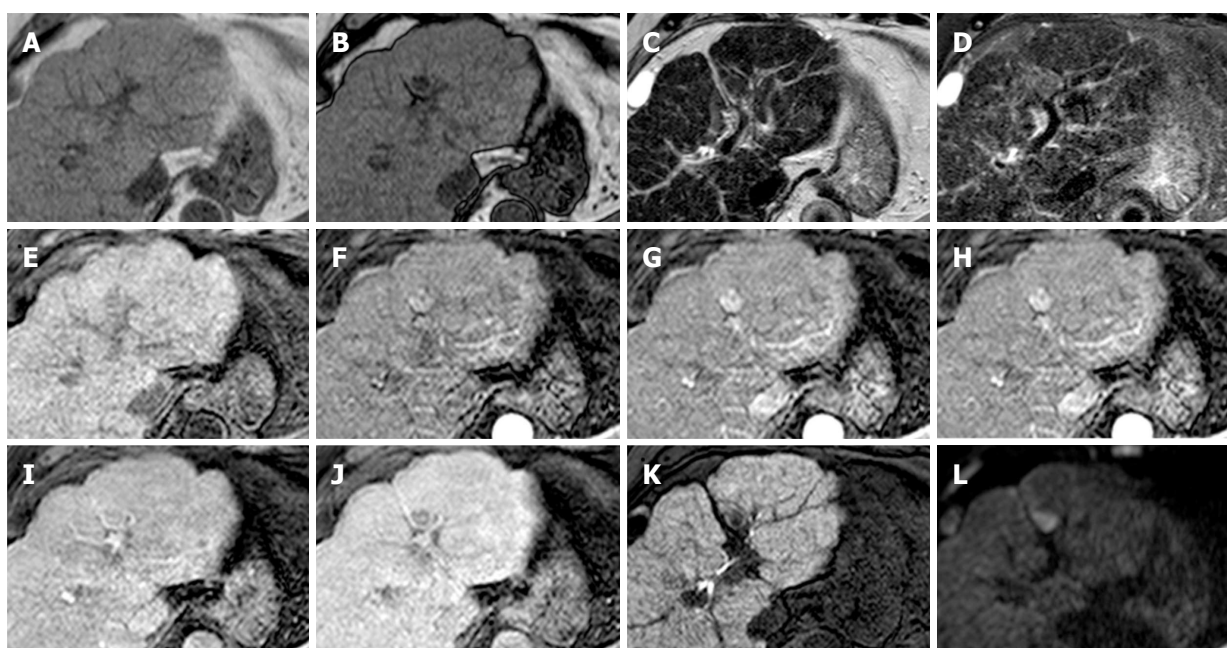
Typical case of lipid-rich hepatocellular carcinoma. A and B: The signal loss of nodule on opposed-phase compared to in-phase indicates intraleisonal fat; C and D: There is mild signal intensity on T2 and DWI restriction (L); E: The nodule appears hypointense in pre-contrast phase; G-J: Note the typical arterial phase hyperenhancement (G and H) followed by washout appearance in the portal venous (I) and/or delayed phase (J) that is the key diagnostic feature of HCC; K: The lesion also demonstrate hypointensity in the hepatobiliary phase; F-H: Note how the multi-arterial phase imaging (F and H) able improve the conspicuity of the HCC, especially in the late arterial phase (H). DWI: Diffusion weighted images; HCC: Hepatocellular carcinoma.
